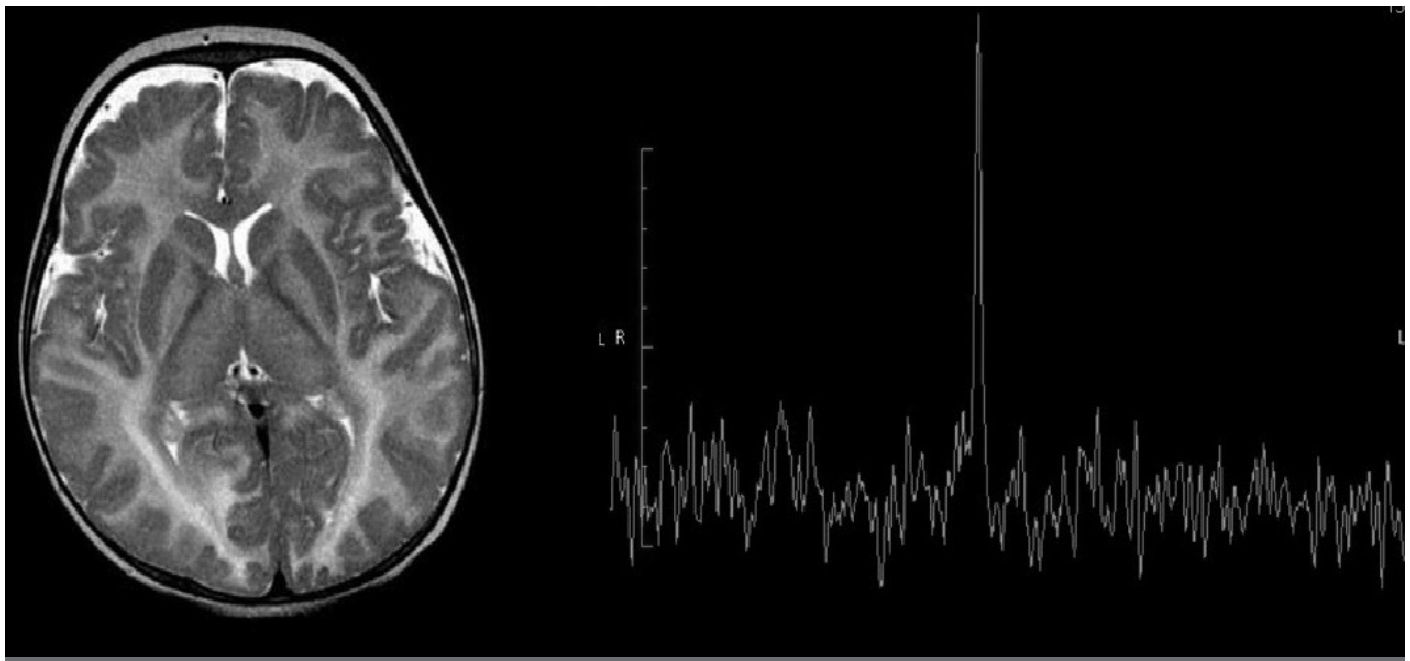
MRI findings and prominent NAA peak of the presented case.
